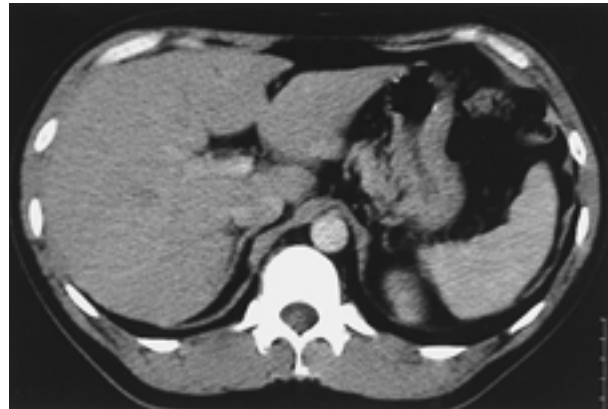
Abdominal contrast CT does not reveal a luminal organ corresponding to the gallbladder in the gallbladder fossa.
